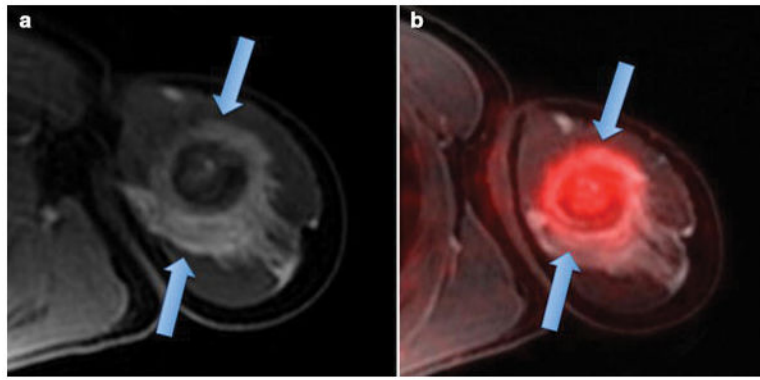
¹⁸F-FDG PET/MR shows differential enhancement of an osteosarcoma and perilesional edema
